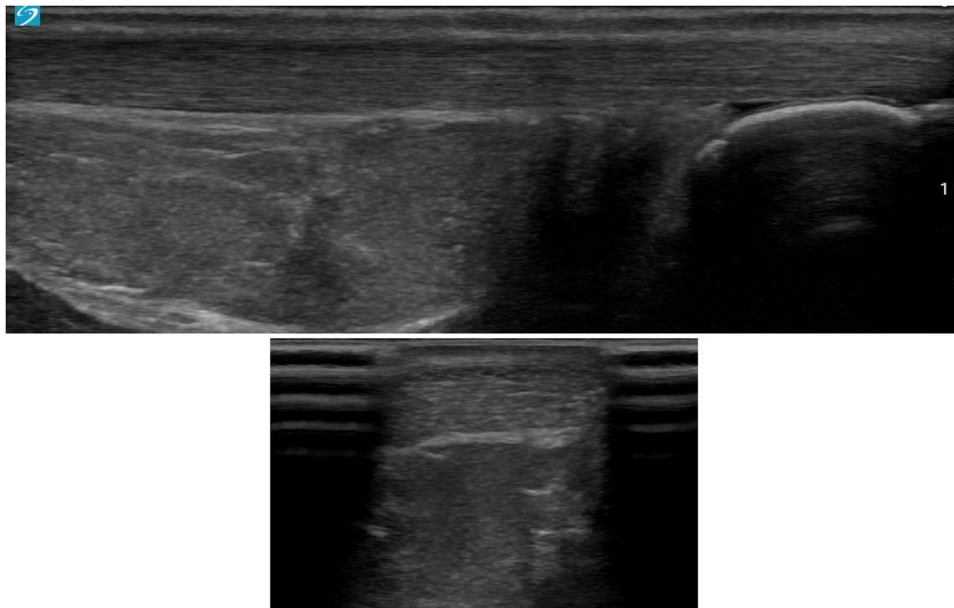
Ultrasound images of an asymptomatic Achilles tendon that later went on to rupture. Notably, no significant abnormalities of the tendon can be seen. Top frame shows a longitudinal (sagittal) view of the Achilles tendon, while the bottom frame shows a transverse (axial) view of the Achilles tendon at the mid-portion.
